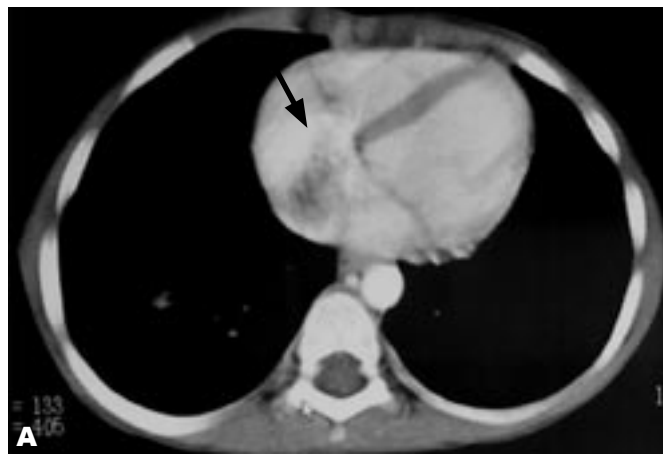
A&B. Axial CT image shows a hypodense filling defect extending from IVC in to the right atrium (black arrows).
